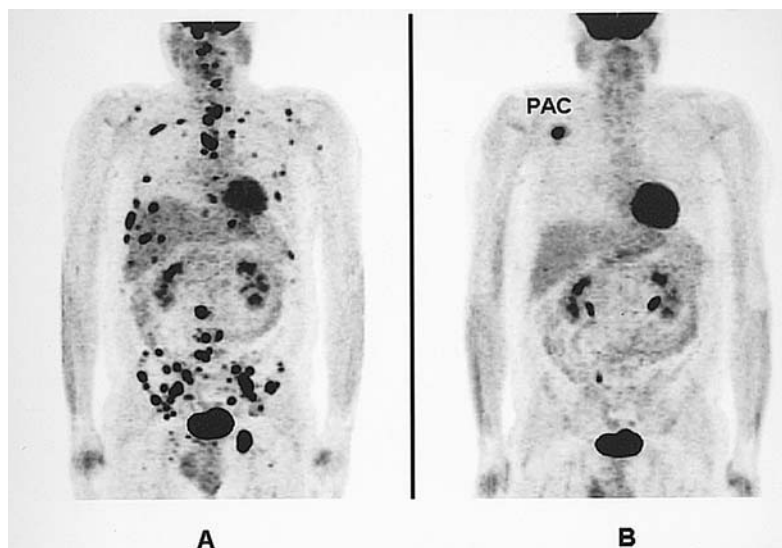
A case of multiple myeloma treated by chemotherapy. A, at baseline, whole-body  $^{18}\text{F}$ FDG PET showed multiple foci consistent with bone marrow tumor deposits. B, after 3 courses of chemotherapy,  $^{18}\text{F}$ FDG PET demonstrated a complete metabolic response. PAC, port-a-catheter.
